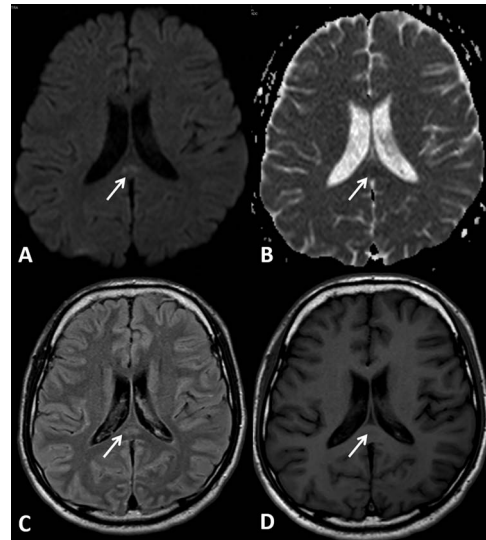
Brain MRI conducted on the fourth day of admission. (A) Axial diffusion-weighted image, (B) ADC image, (C) fluid-attenuated inversion recovery (FLAIR) image and (D) T1WI. A splenial lesion was revealed. The signals in the splenium of the corpus callosum were hyperintense on FLAIR, T2WI and DWI, decreased on ADC and had a slightly low intensity on T1WI (arrow).
